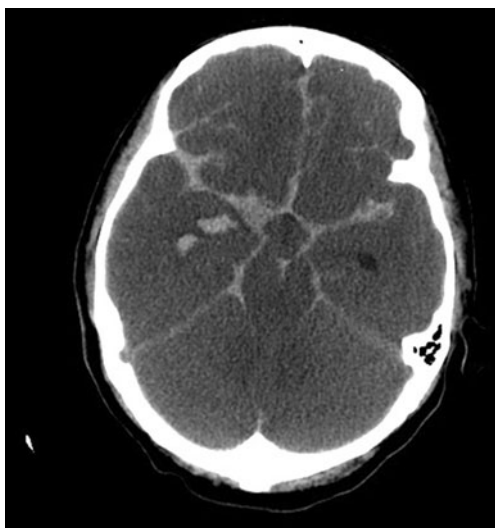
Axial noncontrast CT image demonstrates diffuse subarachnoid hemorrhage in the basilar cisterns and overlying the frontal and temporal lobes, global cerebral edema and a small focus of intraparenchymal blood partially visualized at the level of the medial right temporal lobe
